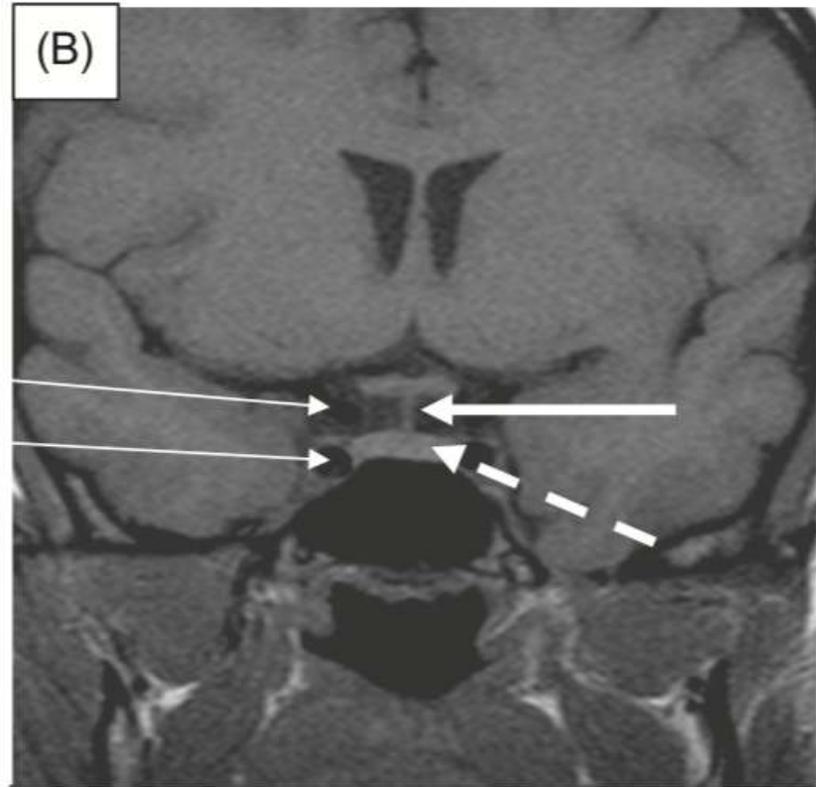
(A) Time-of-flight MRA, sagittal view of internal carotid arteries, and (B) coronal T1-weighted image without contrast.
